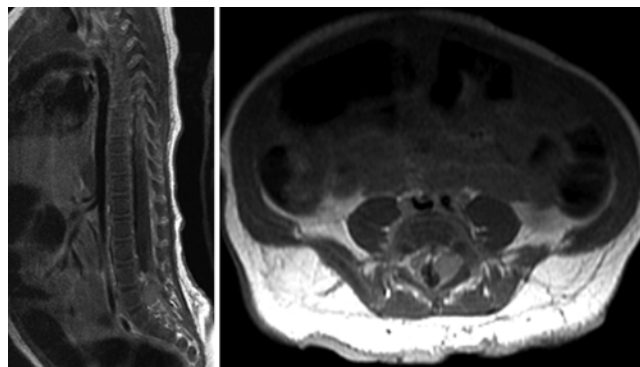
Preoperative sagittal (left) and axial (right) T1-weighted MR images obtained after administration of Gd, showing an enhancing intradural mass lesion at L5–S1.
